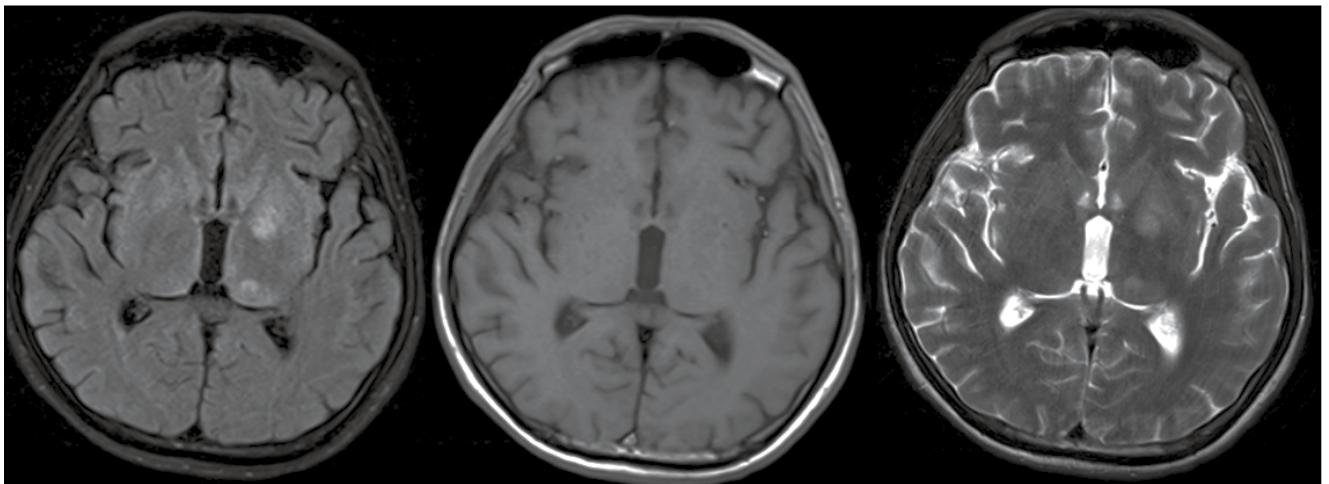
Head MRI on September 5, 2011. Patchy abnormal signals were seen in the left basal ganglia. T1WI showed faint, low-to-intermediate signal, T2WI showed high signal intensity, water- and fat-suppressed imaging showed high signal intensity, and DWI showed faint high signal intensity in left basal ganglia, thalamus, and right-side PLIC. Abnormal arcuate short T1 and long T2 signals were visible under the left temporal region and fat-suppressed imaging showed high signal intensity. Bilateral basal ganglia lesions were more visible than on imaging on August 25, 2011. A left temporal subdural hematoma was seen.
